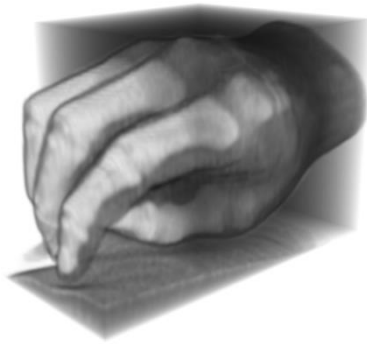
Visible Korean CT scan of hand viewed in Simpleware
